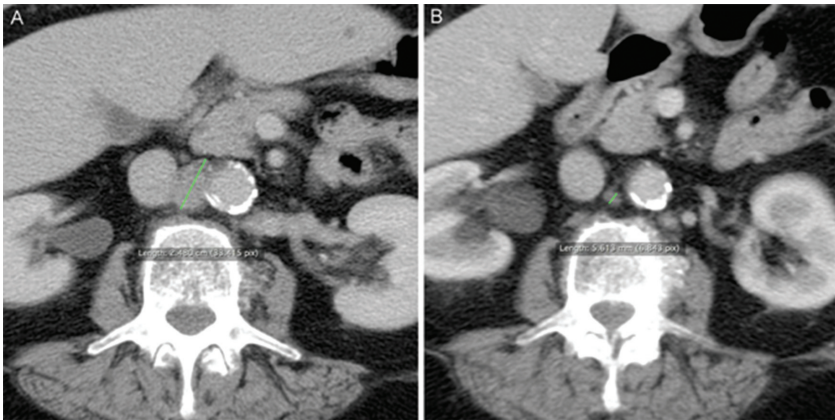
Complete response in patient no. 14 (by RECIST 1.1). (A) Contrast-enhanced computed tomography scan showing periaortic confluent lymphadenopathies (diagonal green line); (b) 2 months later, the lesions became too small to be considered pathological (diagonal green line).
